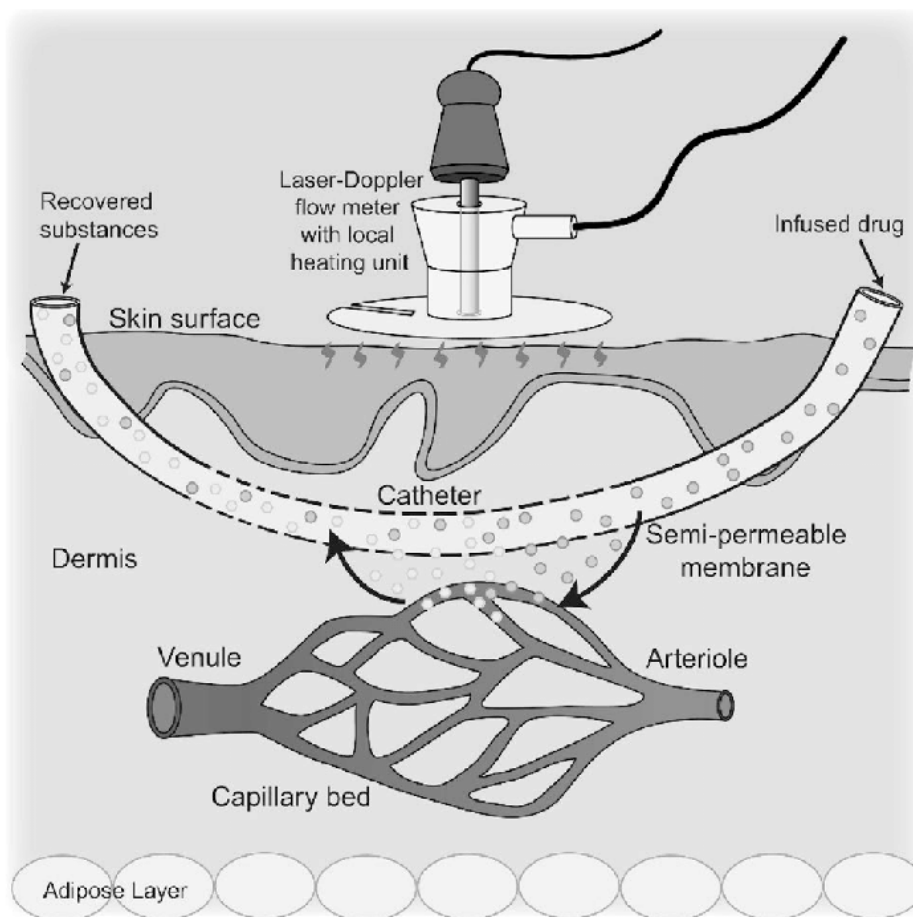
Intradermal Microdialysis Technique Paired with Laser-Doppler Flowmetry (Kenney, 2017).
